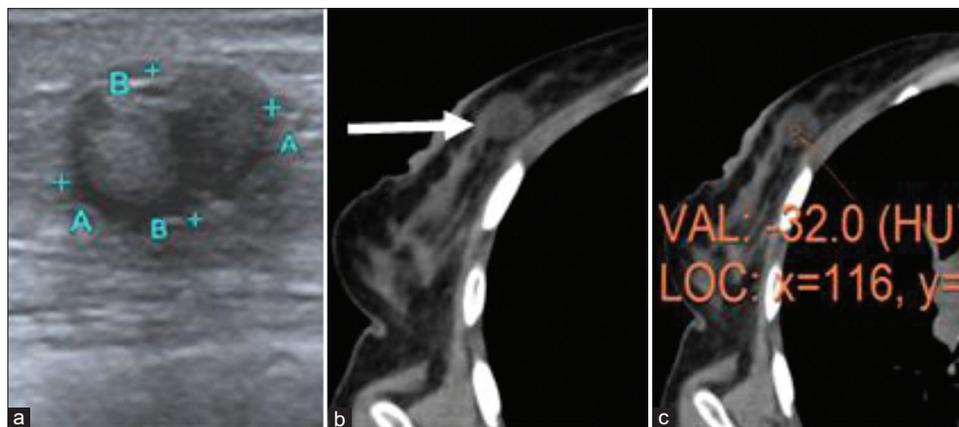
(a) 49-year-old female with no specific complaints. Ultrasound image shows an oval, parallel oriented, circumscribed heterogeneous mass predominantly hyperechoic with no posterior features. Axial section of plain computed tomography in soft tissue window (b) shows a well-defined hypodense mass in the medial quadrant of the breast (arrow). (c) Showing fat density (-32 HU) within the mass
